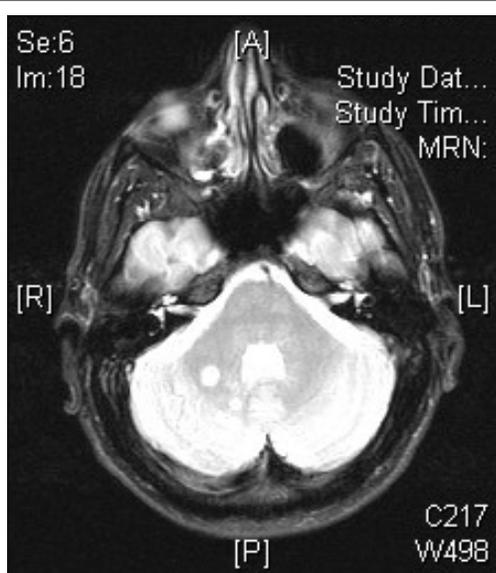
MRI 6 months post treatment showing calcified lesions in the cerebellum, no new lesions remaining.
